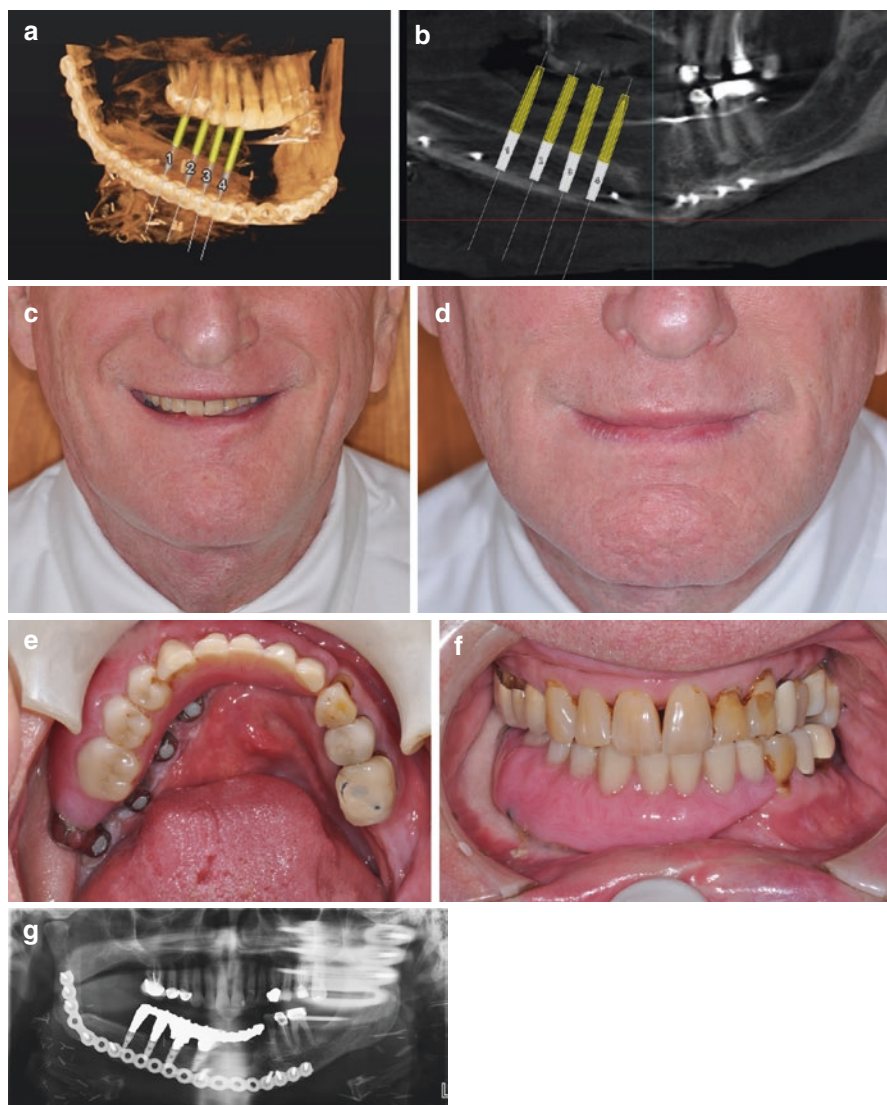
(a) Computer-assisted planning for a 70-year-old gentleman after fibula reconstruction of the right mandible from angle to symphysis. (b) In anticipation for implant rehabilitation, reconstruction plate screws are placed away from implantable bone. (c, d) The marginal branch of the facial nerve was involved resulting in lip asymmetry. Support to the lower lip with an implant prosthesis can camouflage lip asymmetry. (e) The implant fixed dental prosthesis is screw retained for retrievability. (f) The occlusion is restored to bilateral contact. (g) Panoramic radiograph of completed reconstruction (Courtesy of Dr. Devin Okay)
